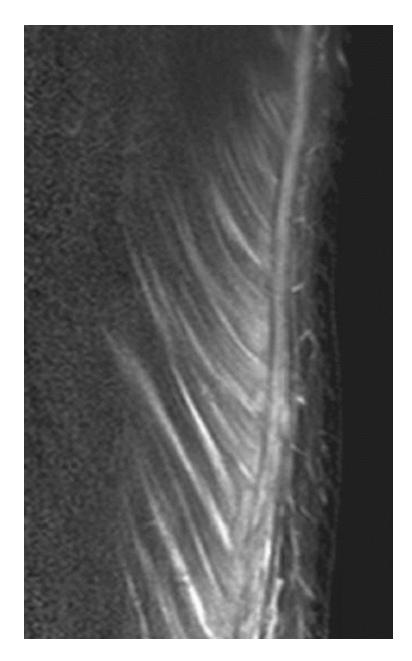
Extensive grade 1 muscle injury on MRI. Coronal T2-weighted fat-suppressed image depicts typical diffuse feathery appearance (of semimembranosus muscle in this example). This effect is due to fluid deposition within the muscle, which leads to a clear definition of the secondary muscle bundles. No circumscribed hematoma is seen in grade 1 lesions
